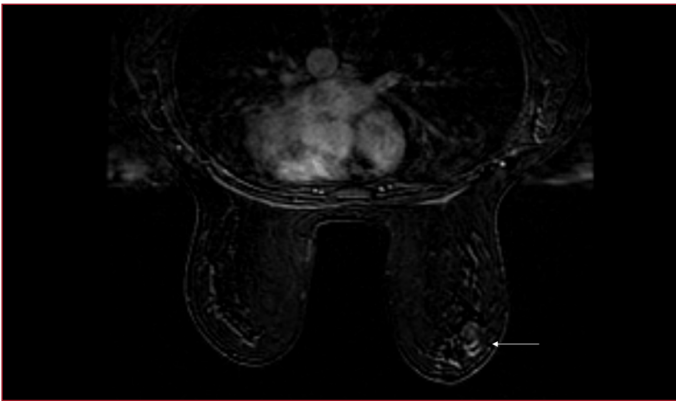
On contrast-enhanced MR images, the lesion (arrow) shows slight and persistent enhancement.
